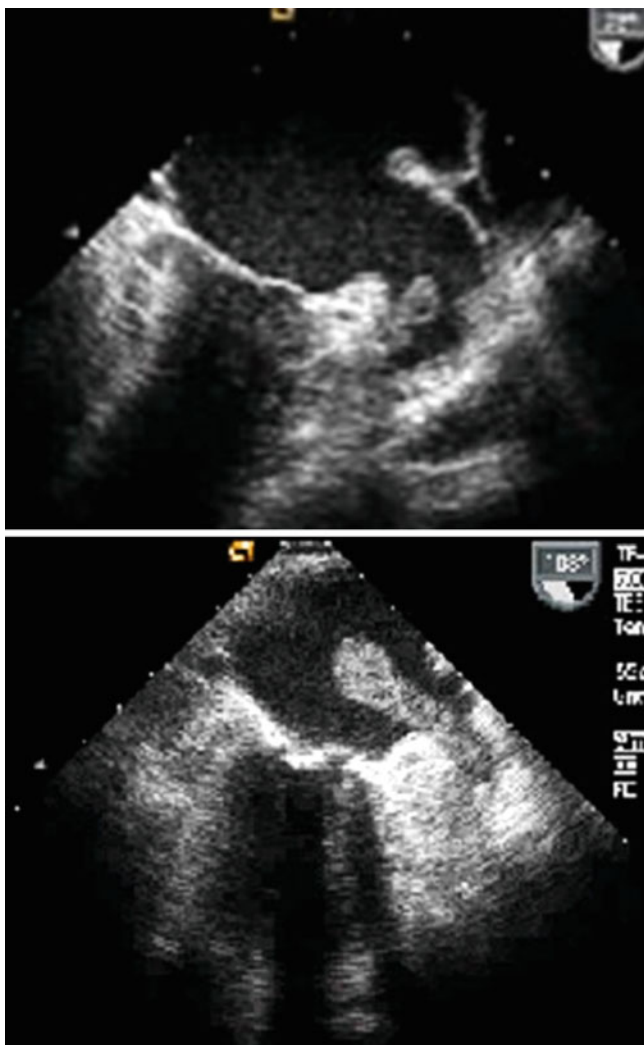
Transesophageal echocardiography assessment of left atrial appendage thrombus
